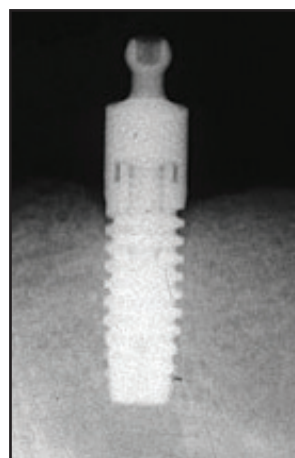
Periapical radiograph of an implant taken six months after implant loading.
